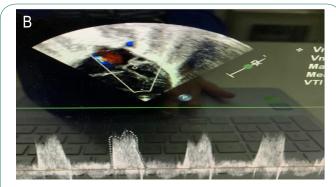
(B) Apical 5 chamber view in two-dimensional echocardiography depicts an abnormal peak velocity blood flow through mitral valve and abnormal E/A ratio , a marker of left ventricular diastolic dysfunction.
